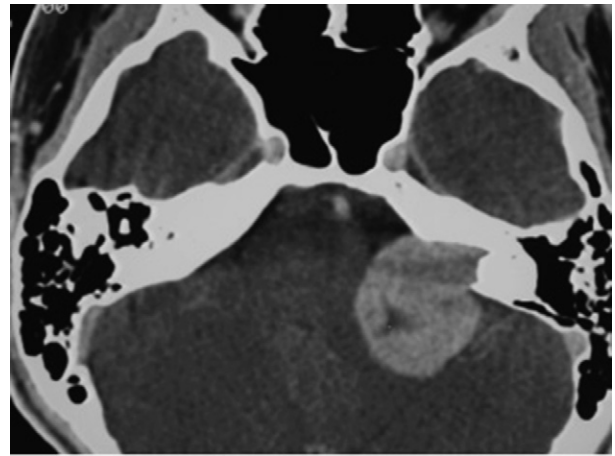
Contrast enhanced axial CT scan showing large tumor occupying the cerebellopontine angle and posterior cranial fossa of a 12-year-old boy.
